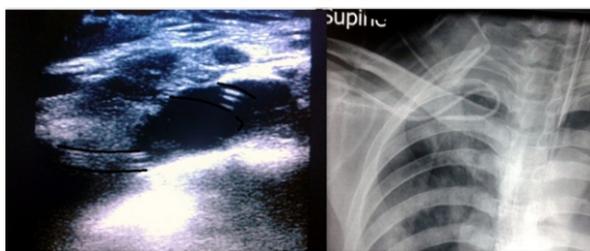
Appearance of coiling of catheter in ultrasonography and chest radiography
